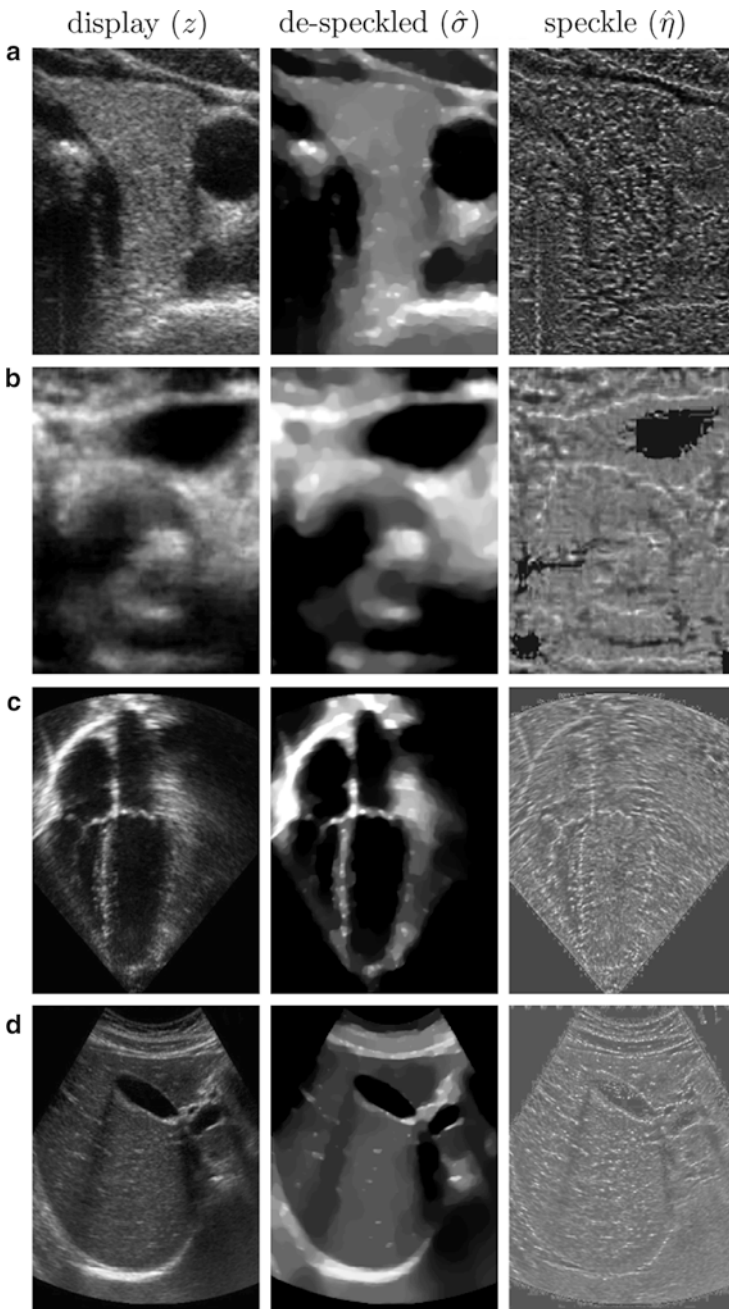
Ultrasound speckle decomposition method applied to different tissue types
